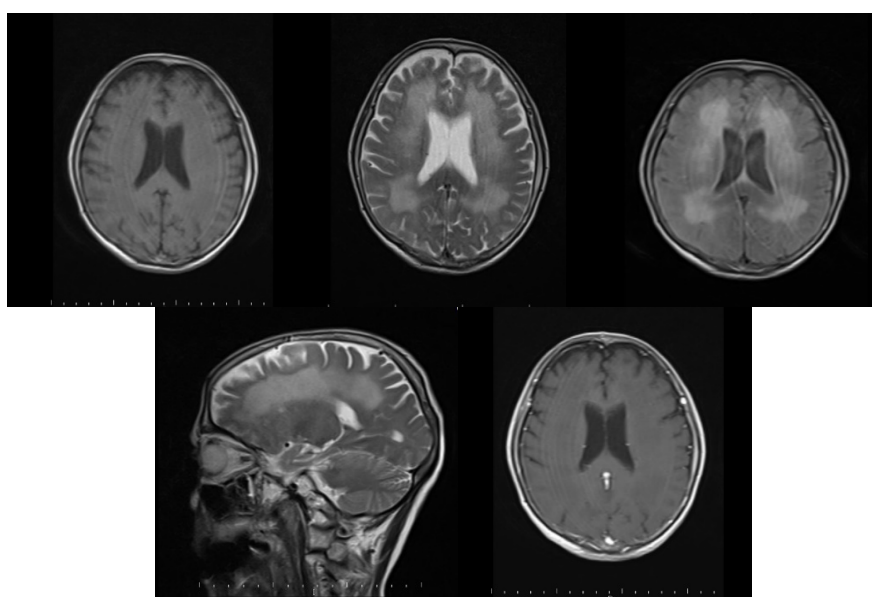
Diffuse demyelinating lesions without contrast enhancement at periventricular white matter and centrum semiovale mildly hypointense in the T1W sequence and hyperintense in T2W and FLAIR sequences.
